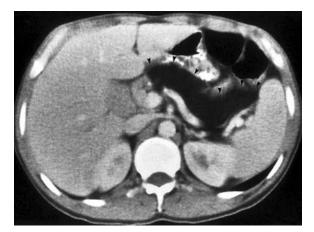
Early pancreatic changes in cystic fibrosis (CF). This CT scan demonstrates a typical CF-appearing pancreas. The pancreas has been replaced by fat and appears to be absent. (*Courtesy Mark Lowe, MD, Pittsburgh, Pa.*)
